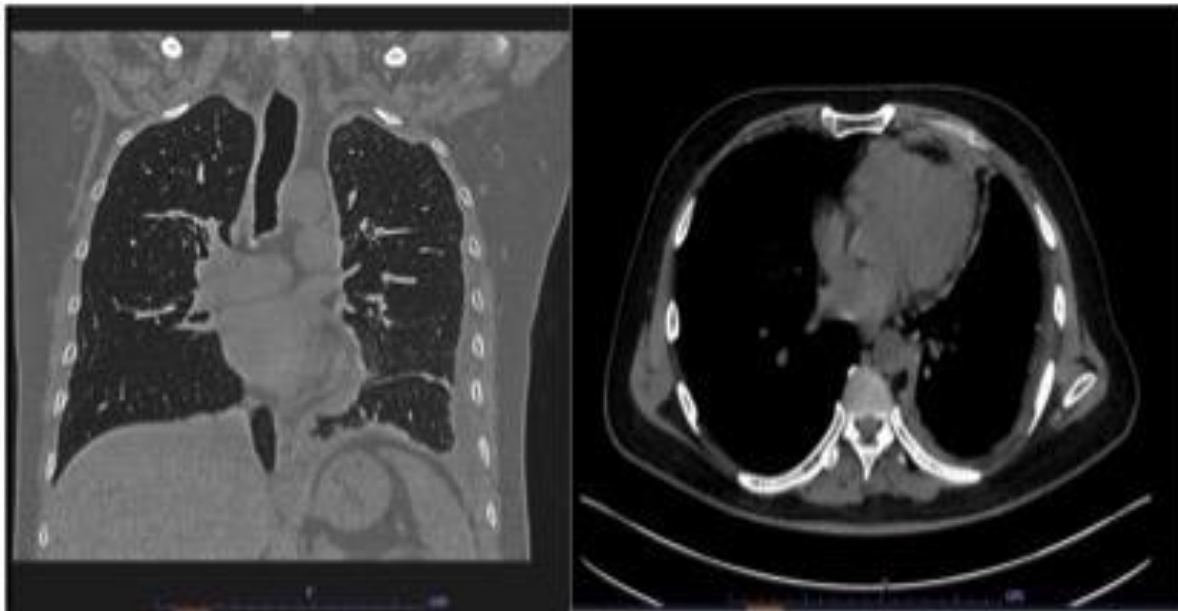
&2B: HRCT showed diffuse circumferential nodular pleural thickening encasing the left lung with mild to moderate pleural effusion and direct invasion of the left pericardium.
